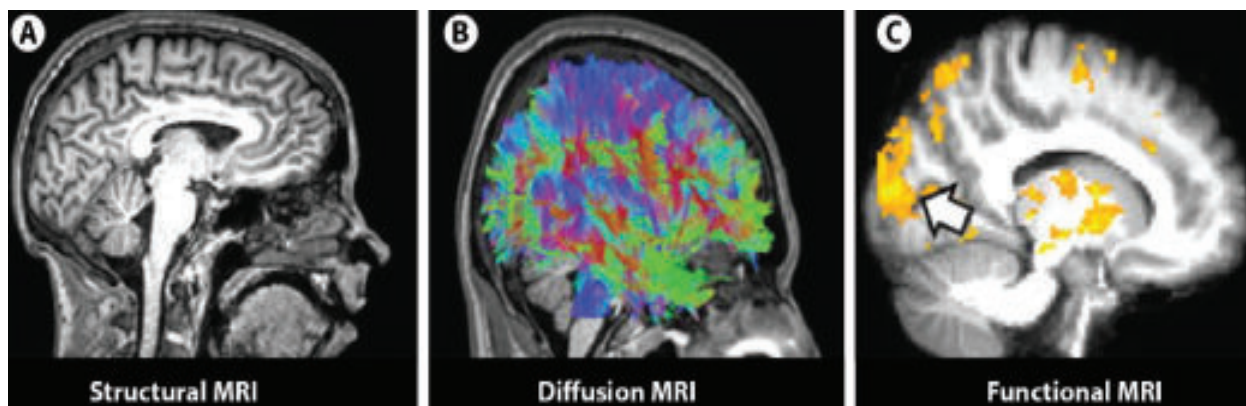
MRI based imaging techniques:(A) Structural MRI reveals the gross anatomical structure of the brain with high detail (B) Diffusion MRI reveals the overall layout of white matter connections and pathways within the brain (known as Diffusion tractography). (C) Functional MRI reveals areas of the brain that are active when and individual is asked to perform a particular task. In this case, an individual who is congenitally blind was asked to identify a tactile pattern through touch. Note areas of activation identified throughout the brain (yellow) including within the occipital cortex which is normally associated with visual information processing (arrow).
